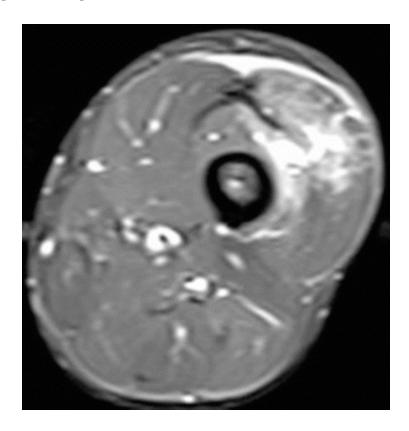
Axial fat-suppressed T2-weighted MRI of left mid-thigh shows combined severe muscle contusion of the vastus lateralis and vastus intermedius
